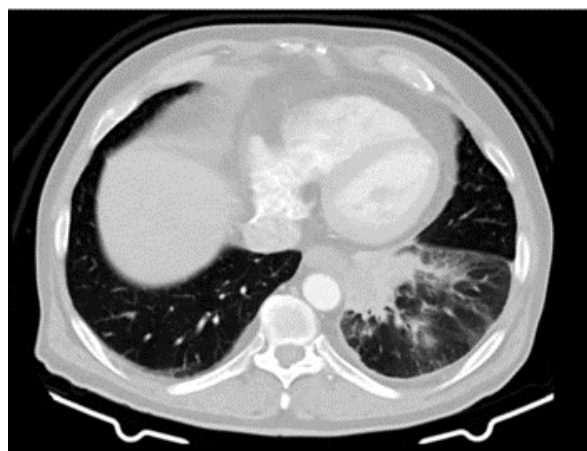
CT images of pulmonary tumor
